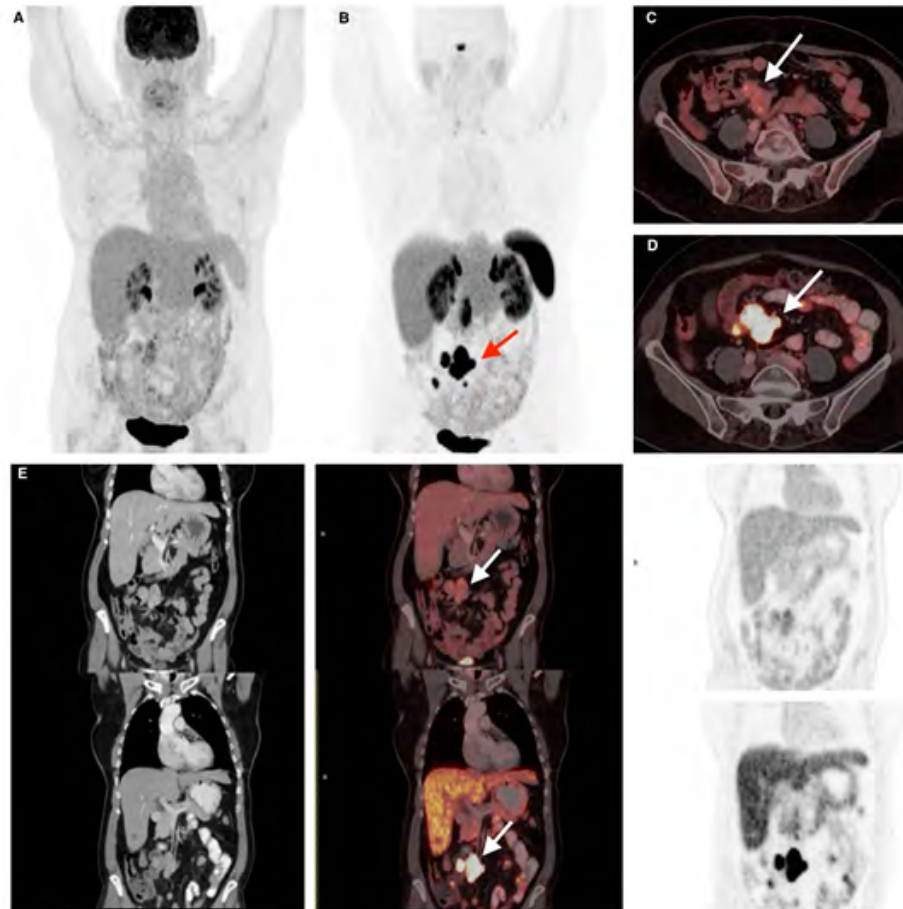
A: MIP (Maxium Intensity Projection) 18F-FDG PET-CT view. B: MIP 68Ga-DOTATOC PET-CT view showing multiple radiotracer deposits in the abdominopelvic region (red arrow). C: Axial slice of the 18F-FDG PET fusion image revealing a 3.8 cm mesenteric adenopathic conglomerate in right iliac fossa (white arrow) with spiculated borders and associated calcifications with low FDG uptake (Standardized Uptake Value max 5.5). D: Axial slice of the 68Ga-DOTATOC PET fusion image showing that the conglomerate (white arrow) shows intense avidity for this radiotracer. E: Coronal slices (upper row 18F-FDG scan and lower row 68Ga-DOTATOC study) showing the conglomerate (white arrow) and in the 68Ga-DOTATOC image at least 3 deposits adjacent to the mass located in ileum corresponding with areas of enhancement.
